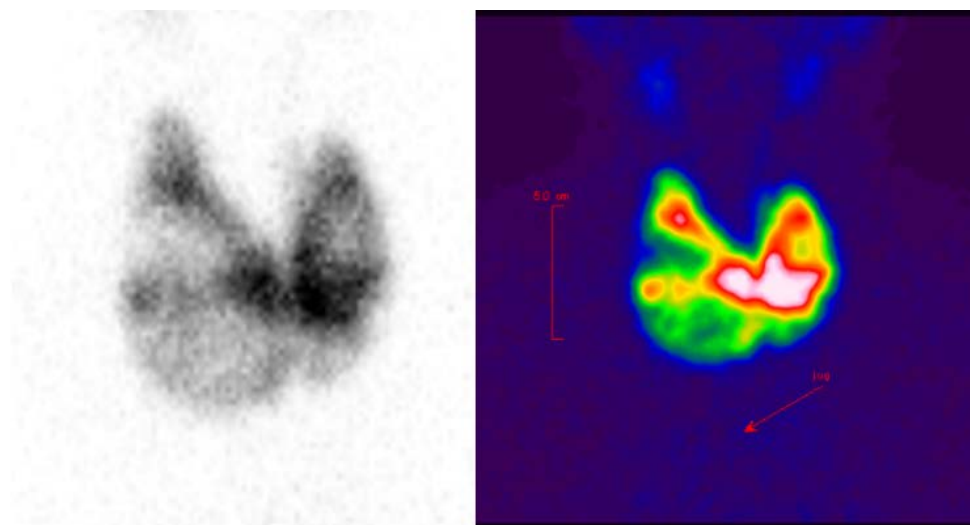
A 35-year-old man, Clinic of thyrotoxicosis, laboratory picture of thyrotoxicosis, ultrasound examination shows a picture of multinodular goiter with solid nodules of heterogeneous structure. Laboratory picture of thyrotoxicosis. Radioisotope study in the gland showed a nonhomogeneous uptake of Tc99- 9.9%, with defects of inclusion, indicating the coexistence of "cold" nodes on the background of diffuse toxic goiter.
